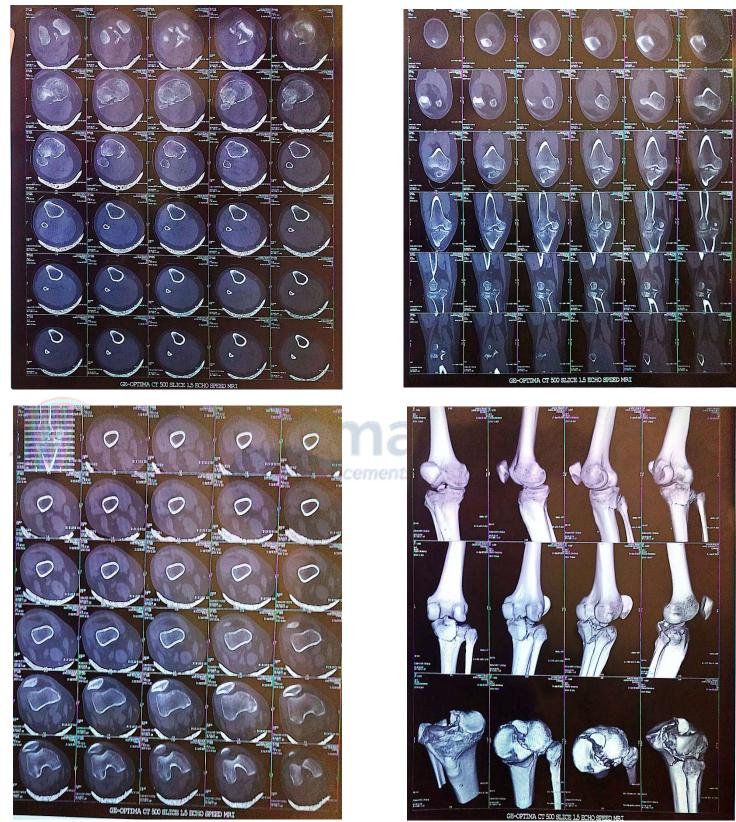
B & C - Axial view CT scan films showing Tibia Plateau comminuted fracture
